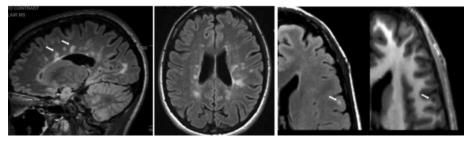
MS gray and white matter lesions in the brain shown by MRI imaging [8].
